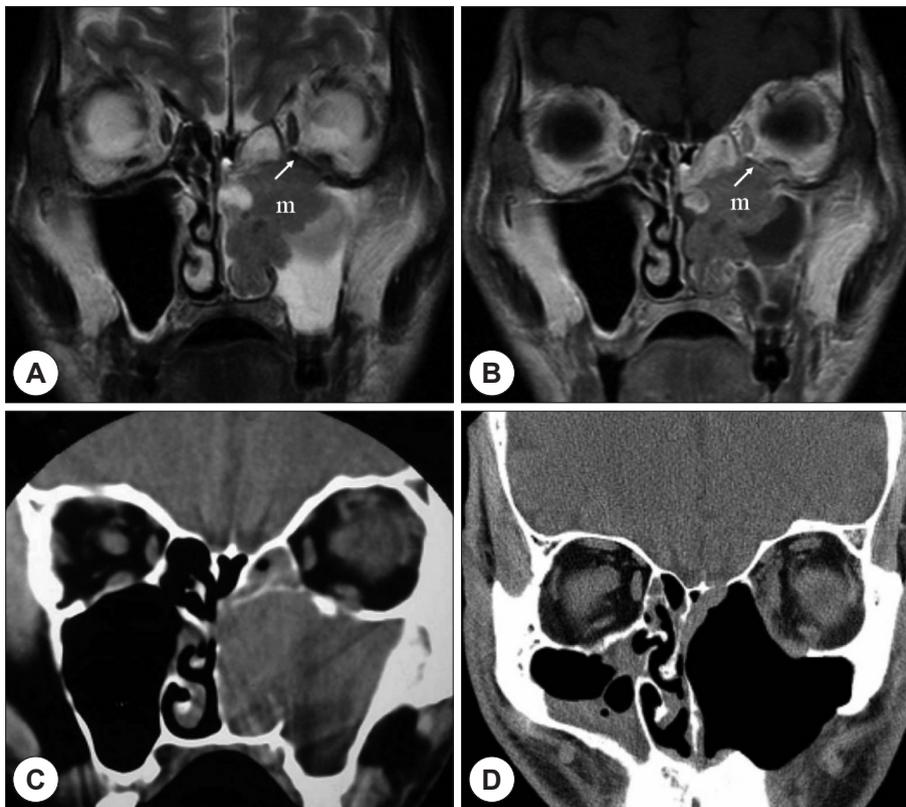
CT/MRI of case 4. The periorbita (arrow) showed hypointensity compared to the mass (m) and left maxillary and ethmoidal sinusitis showed high signal intensity on T2-weighted MR coronal image (A). On Gadolinium-enhanced T1-weighted MR coronal image the periorbita (arrow) showed less enhancement than extraocular muscles or the mass (B). The periorbita is not able to be discerned on coronal CT images (C). There is no evidence of residual or recurrent tumor on follow-up coronal CT images after 24 months (D).
